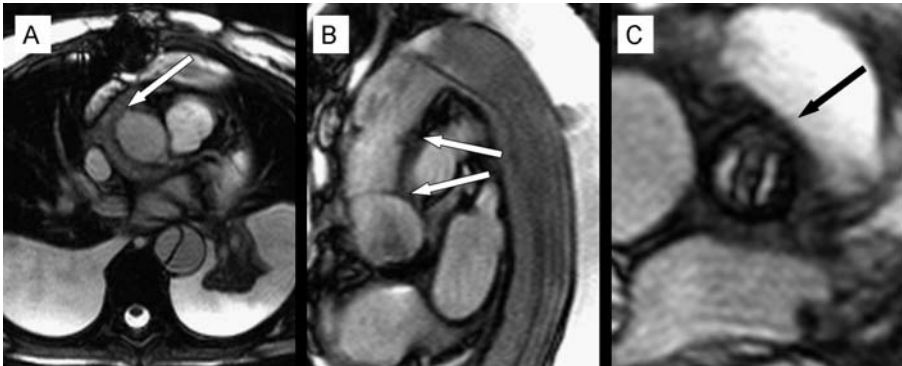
MRI images of a patient 5 days after an operation for type A aortic dissection with aortic valve replacement and conduit. A: Transverse plane. Around the ascending aorta a circular structure can be seen. This represents periaortic hematoma (white arrow). B: Sagittal oblique plane shows the two anastomoses in the ascending aorta (white arrows) and the remaining dissection in the descending aorta. C: Bileaflet aortic valve opens normally in systole (black arrow).
